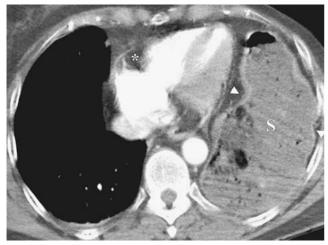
Admission chest CT confirms the elevation of the stomach (S) with a shallow narrowing on both sides (arrowheads). A notching at the atrio-ventricular junction (asterisk) was retrospectively considered a possible sign of diaphragmatic rupture.
